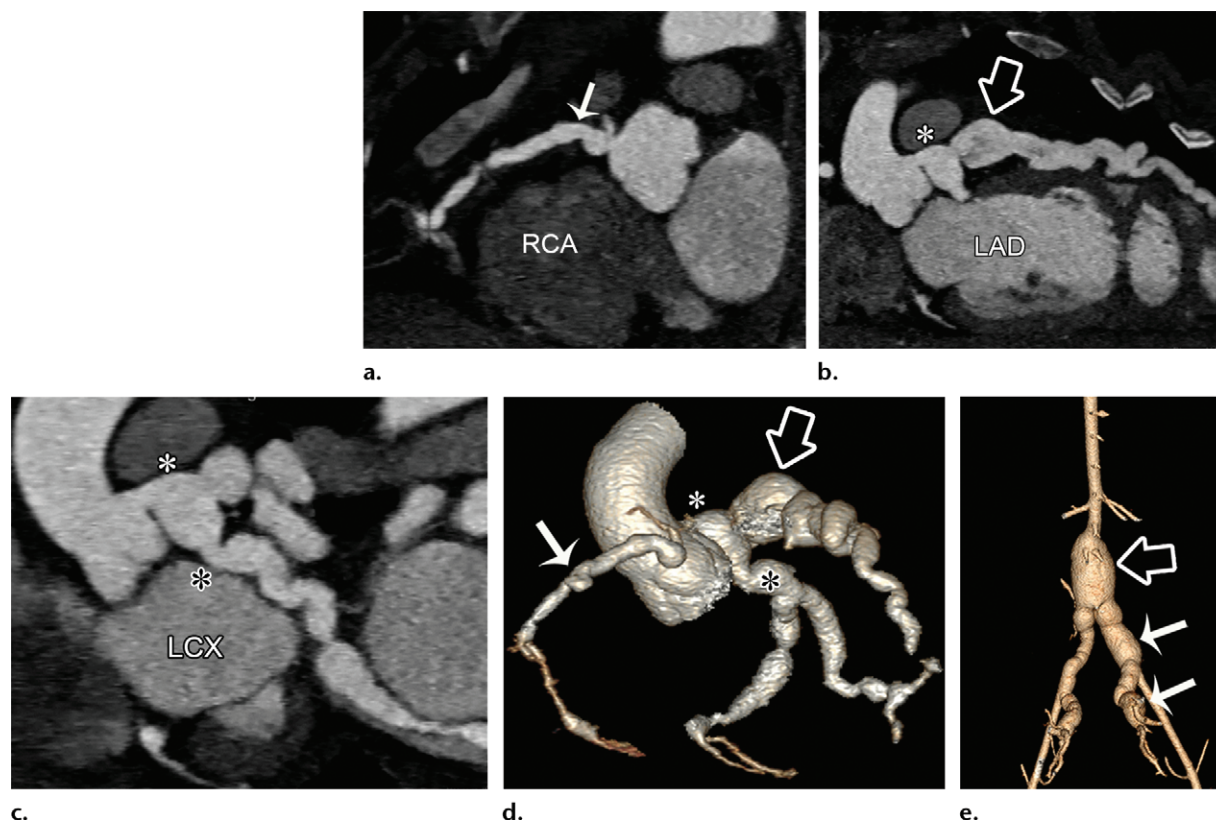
Multifocal aneurysmal dilatation in a 9-year-old girl with SLE. (a–d) Curved planar reformatted images (a–c) and 3D volume-rendered image (d) from coronary CT angiography demonstrate multifocal aneurysmal dilatation of the RCA (solid arrow in a and d), left main coronary artery (white * in b–d), LAD (open arrow in b and d), and LCx (black * in c and d). (e) Three-dimensional volume-rendered image demonstrates aneurysmal dilatation of the infrarenal aorta (open arrow) and internal iliac arteries (solid arrows).
